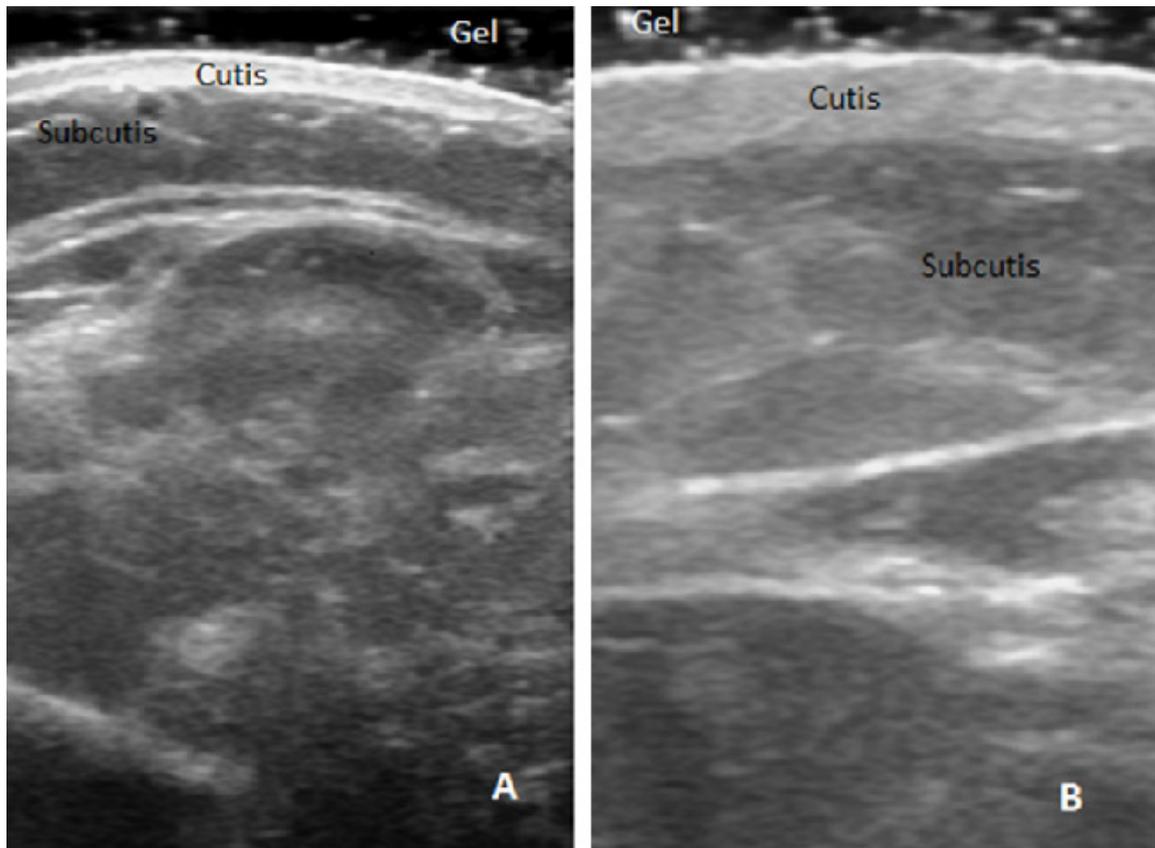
Ultrasonographic images of a patient with unilateral breast cancer-related lymphedema demonstrating cutaneous and subcutaneous thickness A: Unaffected arm B: Affected arm with increased cutis and subcutis thickness.
